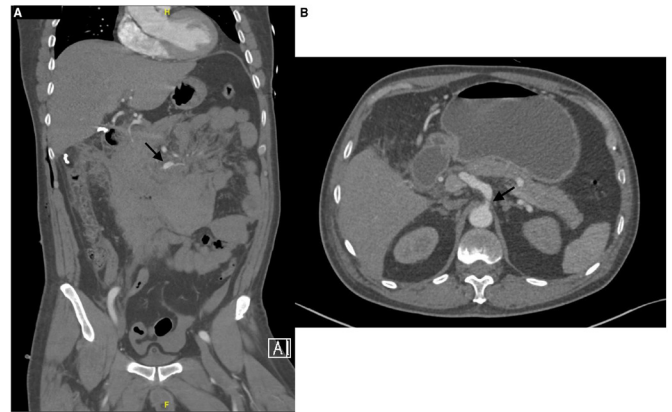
(A) CT coronal section: a massive retroperitoneal haematoma and inferior PDA aneurysm (arrow). (B) CT axial section: a coeliac axis stenosis near the origin with a hypodense linear band-like structure. (arrow). PDA, pancreaticoduodenal artery.
